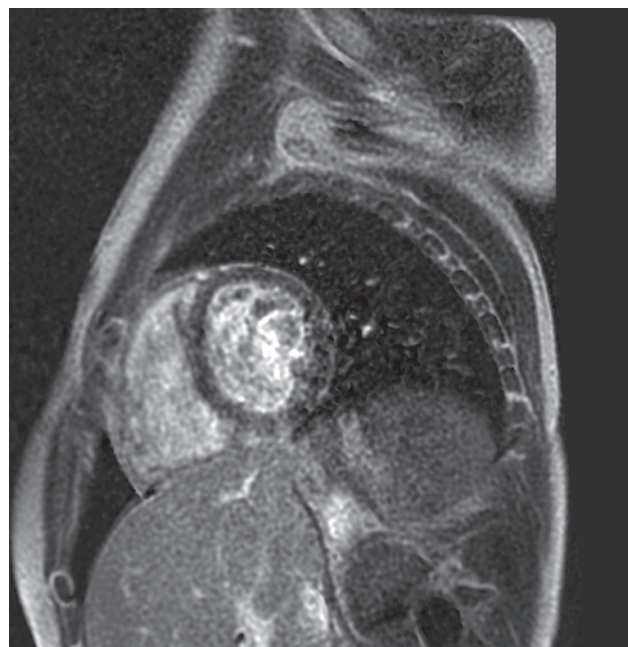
Cardiac MRI (short-axis) with negative finding of late gadolinium enhancement in left ventricular myocardium. NÚSCH, a. s., DKC
